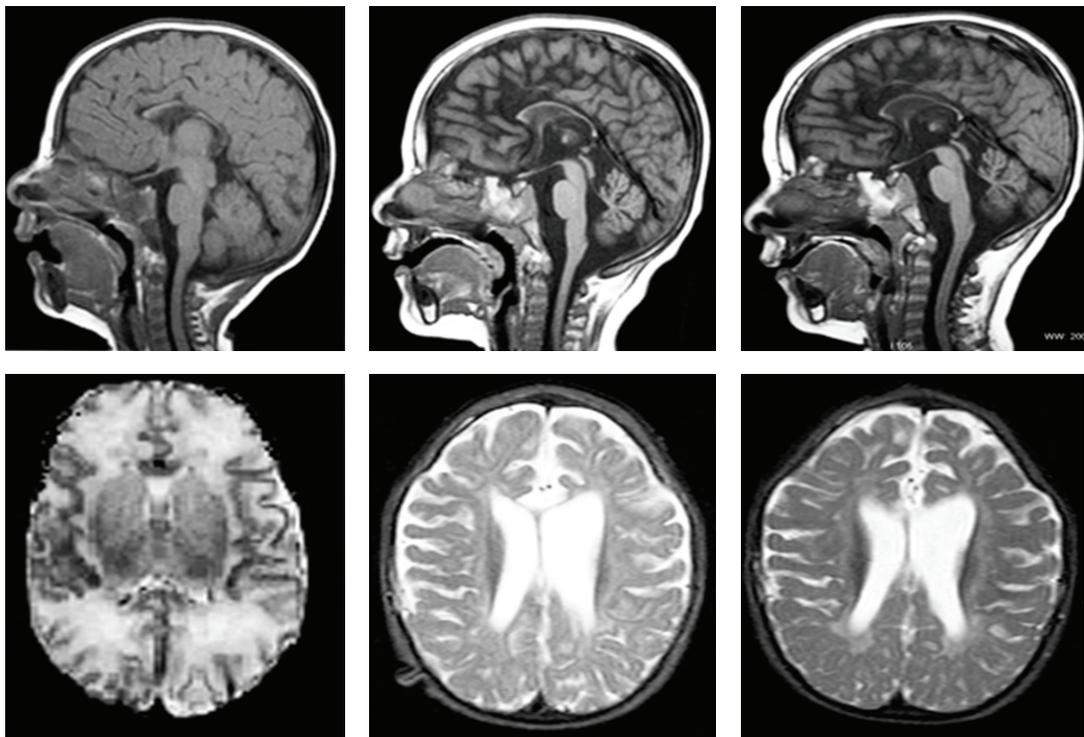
This figure shows the MRIs of a male infant born at 36 gestational weeks with PVL. At 2 months of corrected age it was possible to observe in the MRI the presence of diffuse leukomalacia in the occipital regions; the corpus callosum and the lateral ventricles had normal volumes. At 14 months of age the volume of the corpus callosum was very small (less than 2 SD) and the volumes of the lateral ventricles were greater than 2 SD from the norm, and at 32 months the corpus callosum maintains the small volume and the lateral ventricles maintain the great volumes.
